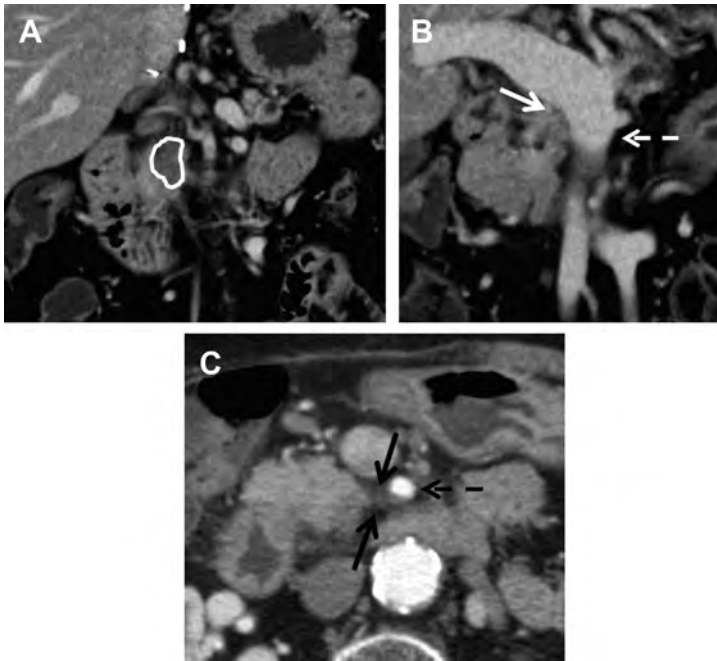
In a 69-year-old woman with abdominal pain, contrast-enhanced CT scan in coronal reformats (*A, B*) and axial (*C*) shows a hypodense pancreatic head/uncinate mass (*outlined*) with less than 180° abutment (*white straight arrow*) of the SMV (*white dashed arrow*) and less than 180° abutment (*black straight arrows*) of the superior mesenteric artery (*black dashed arrow*). This case was considered borderline resectable by the multidisciplinary tumor board.
